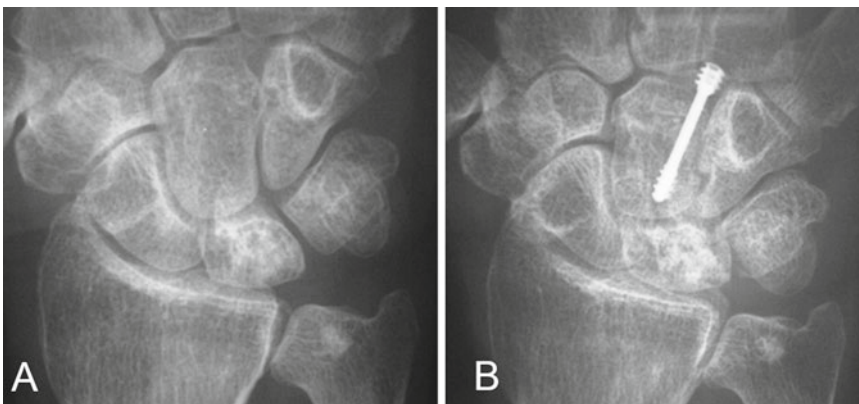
Preoperative (a) and 1.5-year postoperative (b) X-rays of classical capitate shortening procedure performed for a 25-year-old man with stage II Kienböck's
